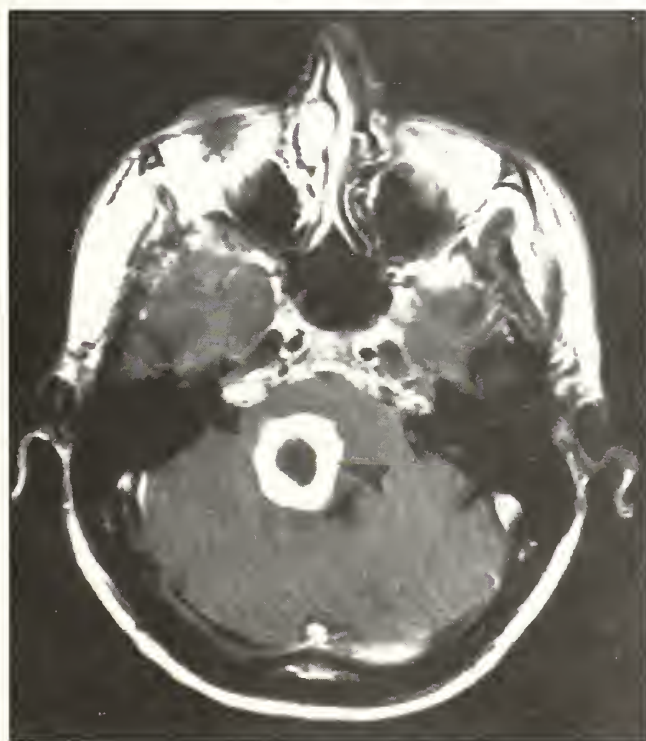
Thirty-two-year-old man with presumed CNS histoplasmosis. Gadolinium-enhanced axial T1-weighted image revealing a ring enhancing pontine mass (arrow).
